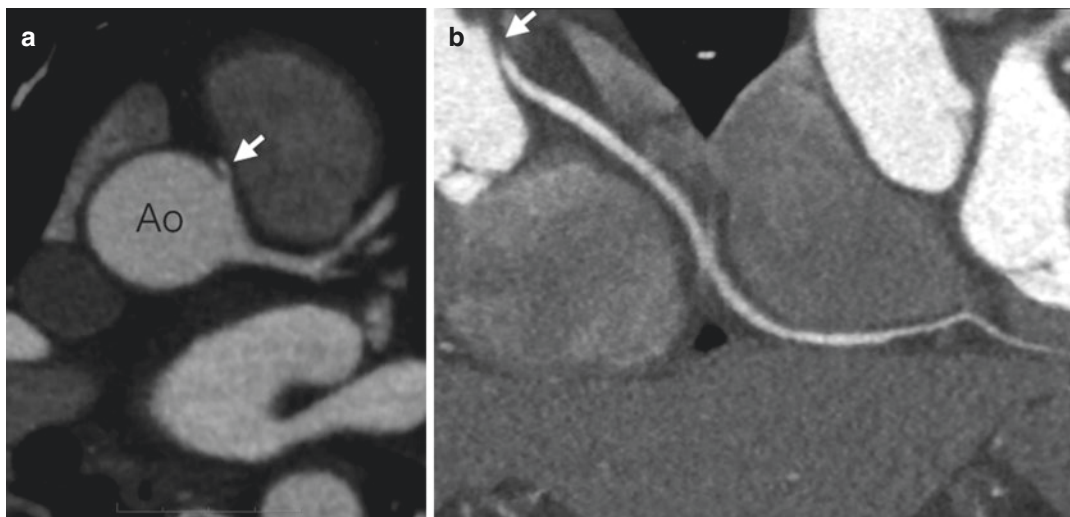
Intramural right coronary artery (RCA) arising from the left coronary sinus. (a) Gated axial CT image at the level of the aortic root (Ao). The RCA arises from the left coronary cusp, and in its most proximal portion, it takes an intramural course through the aortic wall (arrow).
